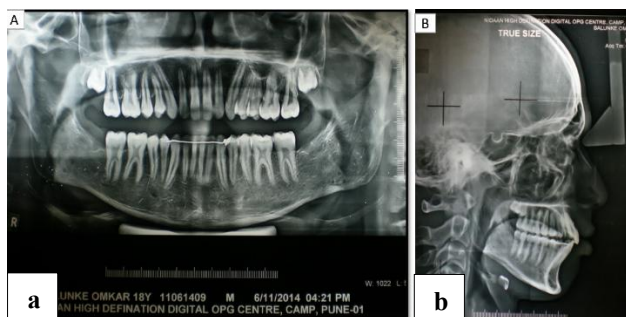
(a and b): Post-treatment radiographic assessment comprising panoramic radiograph (orthopantomogram) and lateral cephalogram.
